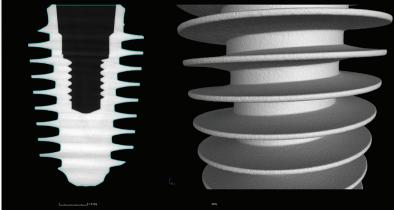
Deep threads of a Megagen[®] Implant as seen on micro-focus CT image on the left and the micro-focus CT 3D image on the right.
